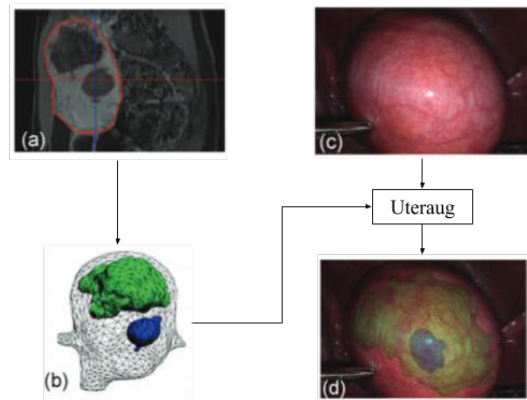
Overview of the Uteraug system: (a) Preoperative MRI data are segmented to obtain the organ, intra-organ tumours and external surfaces (b). Uteraug superimposes the video frame (c) with the 3D registered models (b) to obtain the augmented image showing virtual transparency (d).
